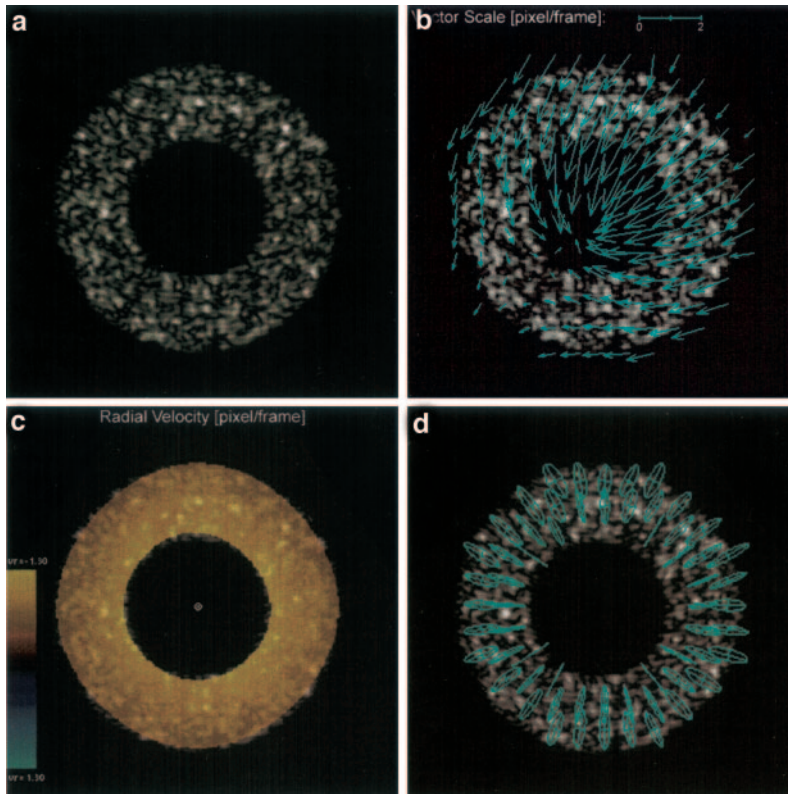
Different kinds of motion information determined by multiscale motion mapping from synthetic ultrasound data (a) during systole: Velocity display (b) reflects superposition of radial contraction and global translation. Radial velocity component (c) indicates uniform inward motion (reference point moving with the cavity was used here). Strain-rate display (d) documents myocardial thickening and circumferential shortening independently of underlying translation.
